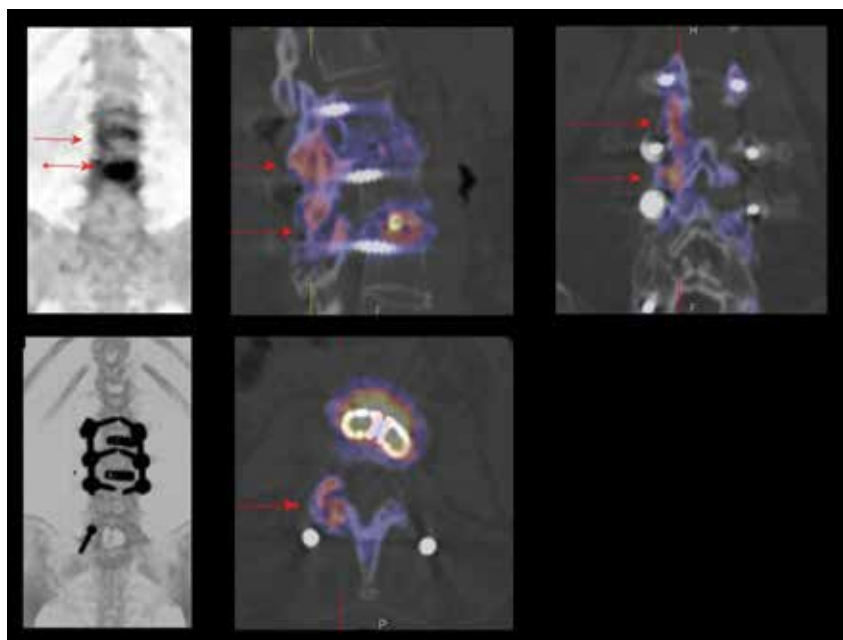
CT and fused images at the level of the body of the L3 vertebrae show increased uptake in the right intra-articular facets of the L2, L3 and L4 vertebrae (arrows), which reflects osseous stress related to vertebral instability secondary to impression fracture of upper end plate of the L4 vertebrae. The facet uptakes are not related to the path of the pedicle screws, and no evidence of loosening of the lumbar fixations screws are evident on CT or fused images.
